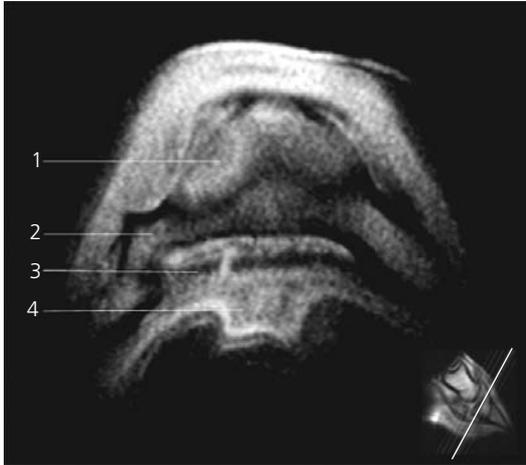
T1-weighted transverse oblique image of Case 2 taken proximal to the deep digital flexor tendon (DDFT) insertion. A clear vertical hyperintensity is seen bisecting the medial lobe of the DDFT. 1 = Middle phalanx; 2 = distal phalanx; 3 = DDFT; 4 = cuneal part of digital cushion.
